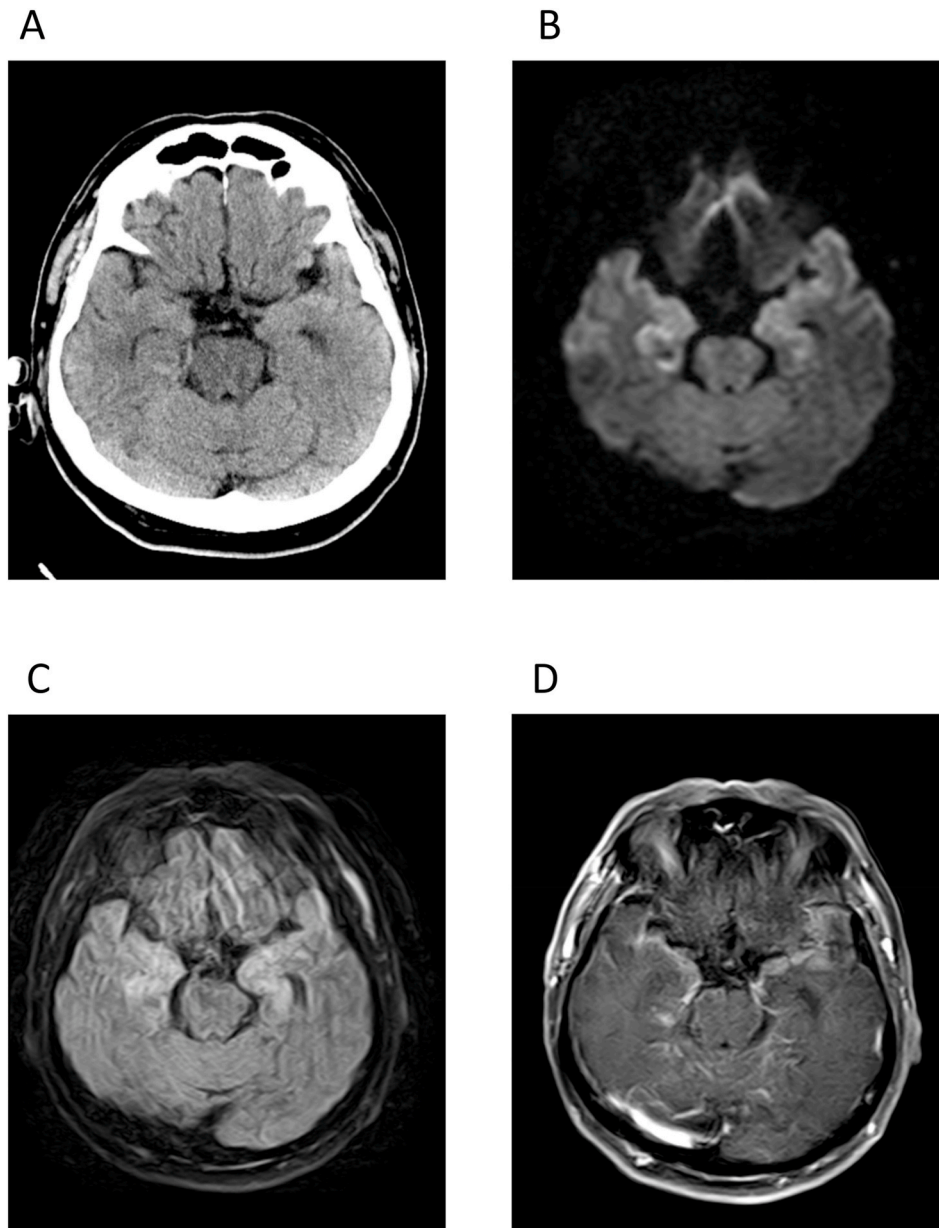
Neuroimaging studies on admission. (A) Non-contrast brain computed tomography scan shows no abnormalities. (B) Diffusion weighted, (C) fluid-attenuated inversion recovery, and (D) gadolinium-enhanced T1-weighted images of brain MRI. MRI reveals bilateral symmetric high intensity areas in the hippocampus, amygdala, and temporal lobe. These lesions are enhanced by gadolinium on T1-weighted image. MRI, magnetic resonance imaging.
